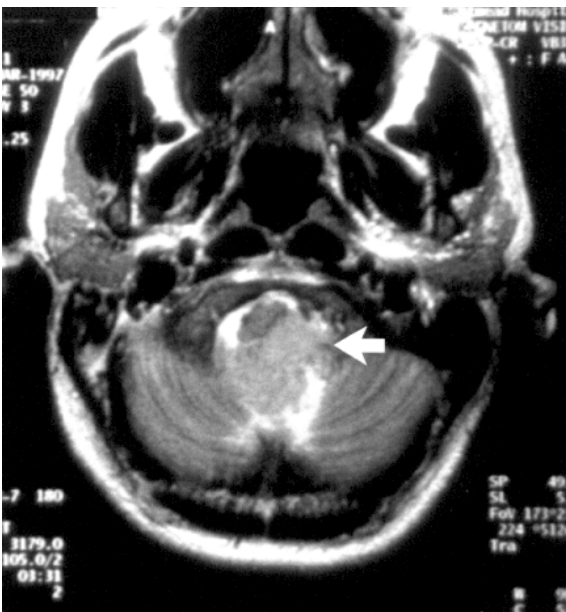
Axial T2W MR image taken through the foramen magnum of the same patient as Fig. 6a shows that the lesion is of intermediate signal intensity, suggesting its cellular nature (arrow). A meningioma was found at surgery.
